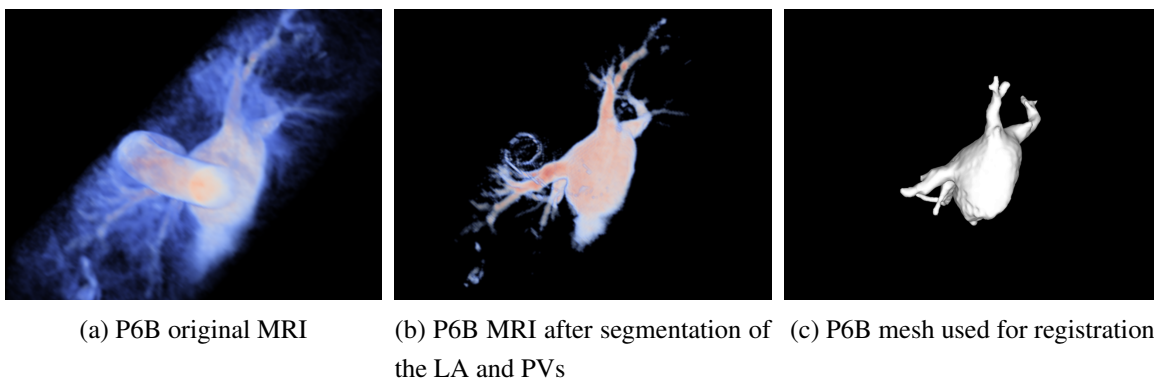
Segmentation of a mesh from a MR image.
